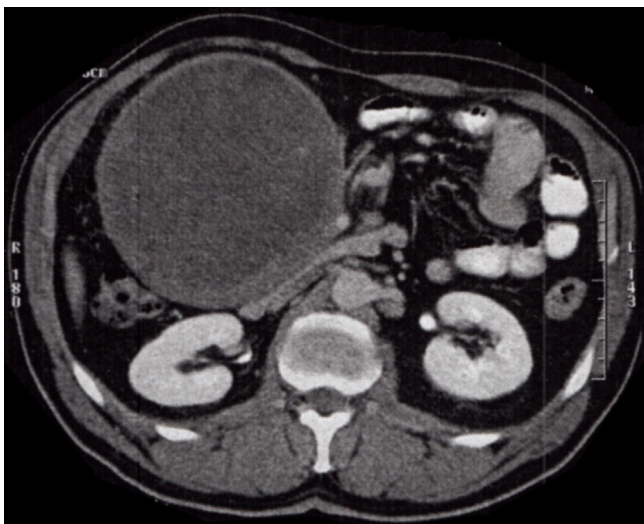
Voluminous mass on the abdominal CT image.
